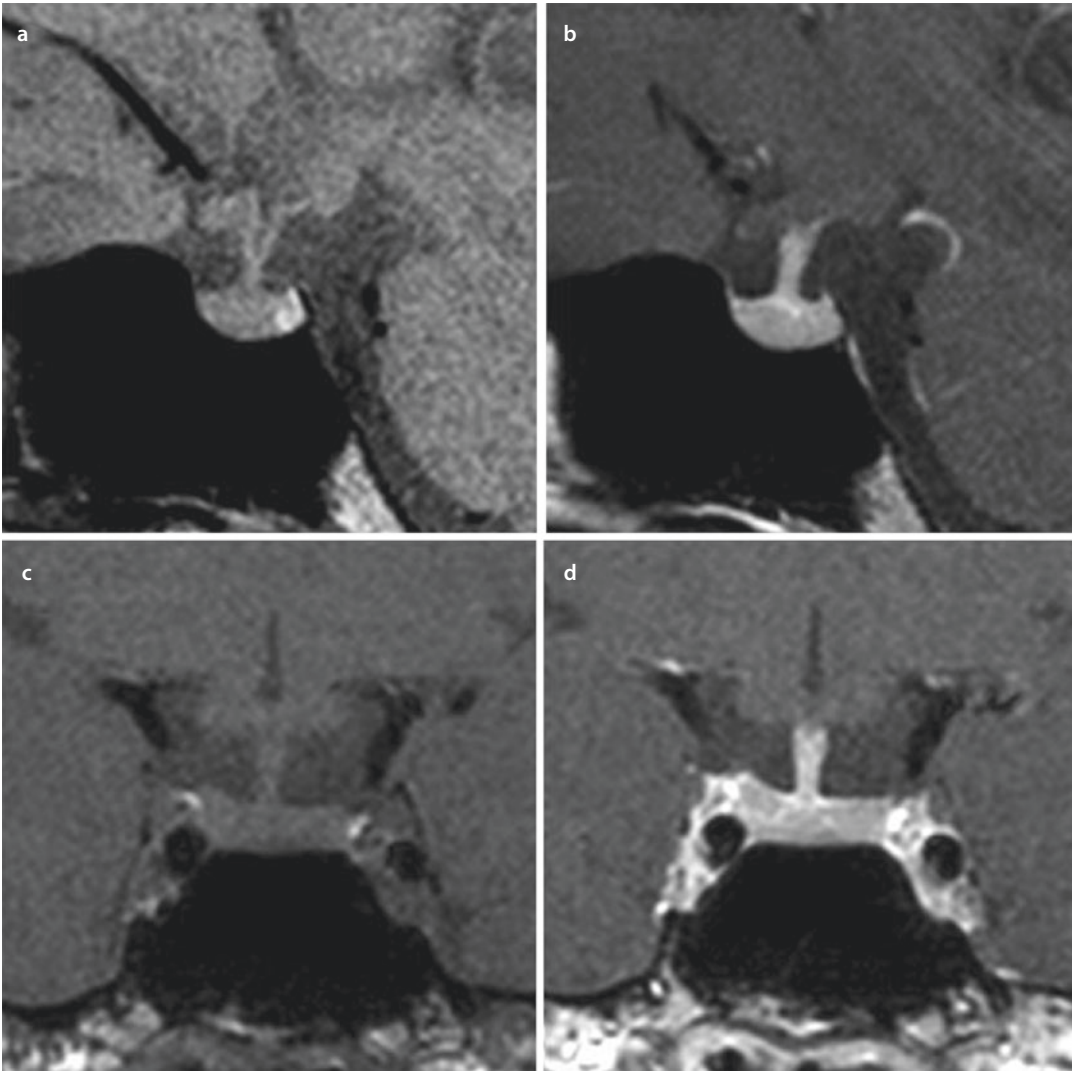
T1-weighted magnetic resonance imaging (MRI) of a normal pituitary. a Sagittal, native, b sagittal with contrast, c coronal native, d coronal with contrast. (Courtesy of Dr. György Várallyai)
